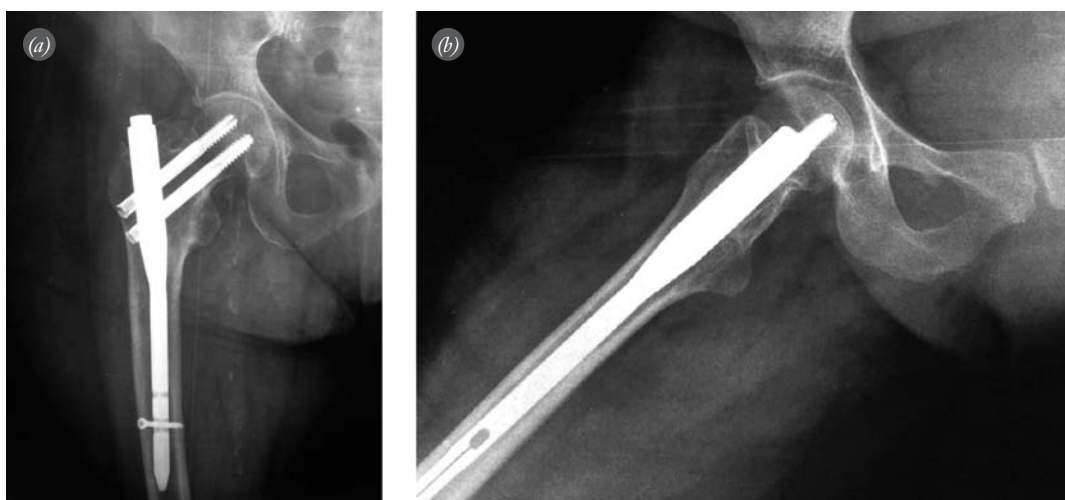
Postoperative 14th month (a) anteroposterior and (b) lateral radiographs of the same patient.
